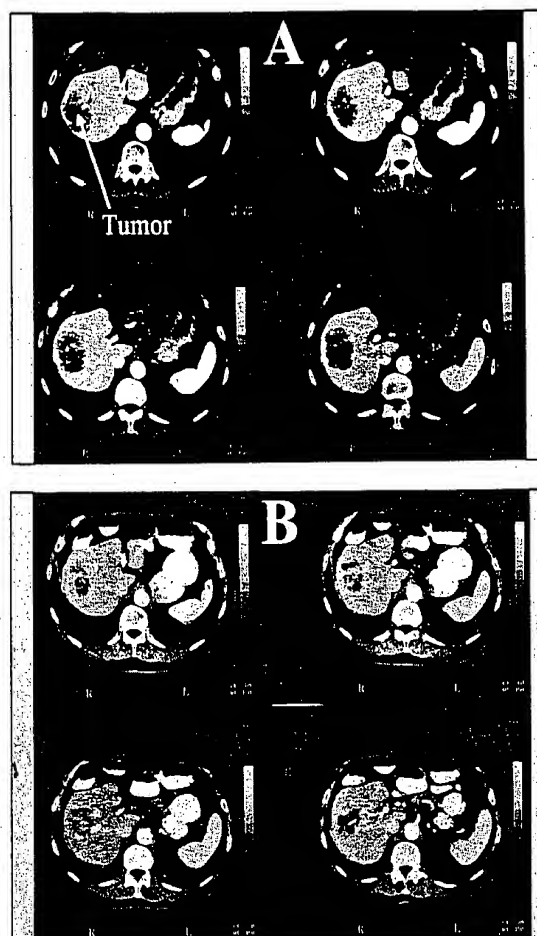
Partial response in a man with colon carcinoma. (A) Baseline CT scan demonstrating 10-cm liver metastasis. (B) CT scan at month 1 demonstrating the response.
